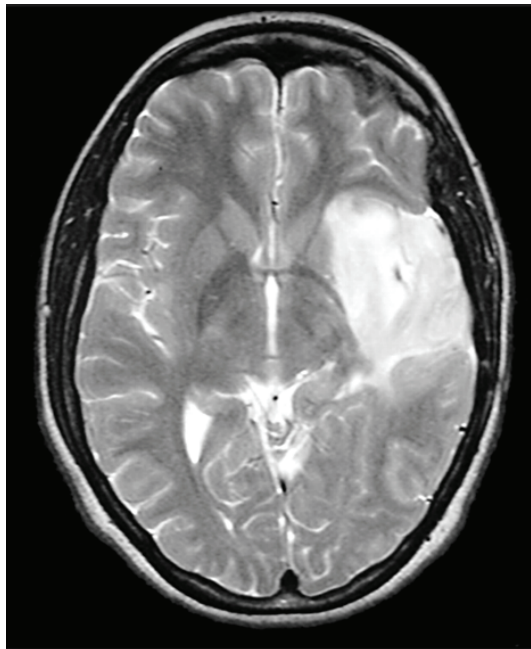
Magnetic resonance imaging (MRI) scan, T2-weighted (T2W) sequence of a lower-grade glioma involving insula and temporal lobe on the patients left side.
